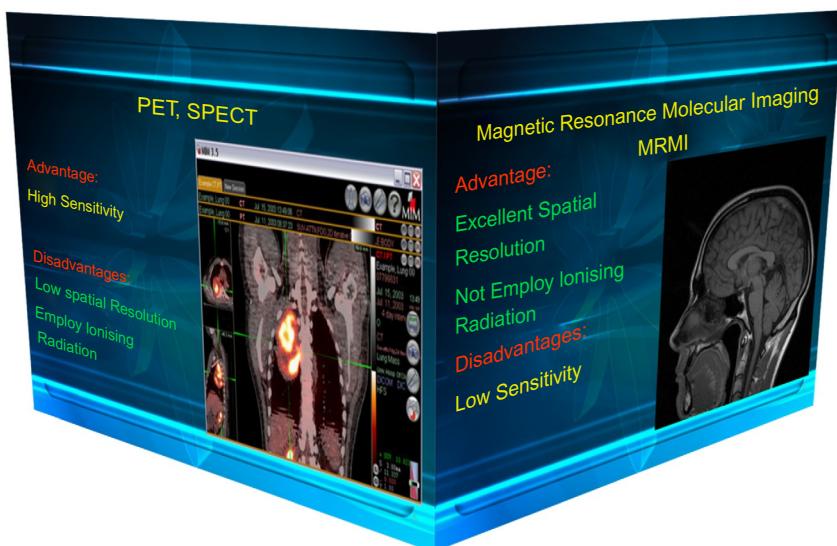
On the left, a picture of PET/MRI and the positive and negative points of PET and SPECT devices and, on the right, MR image and its positive and negative points.
